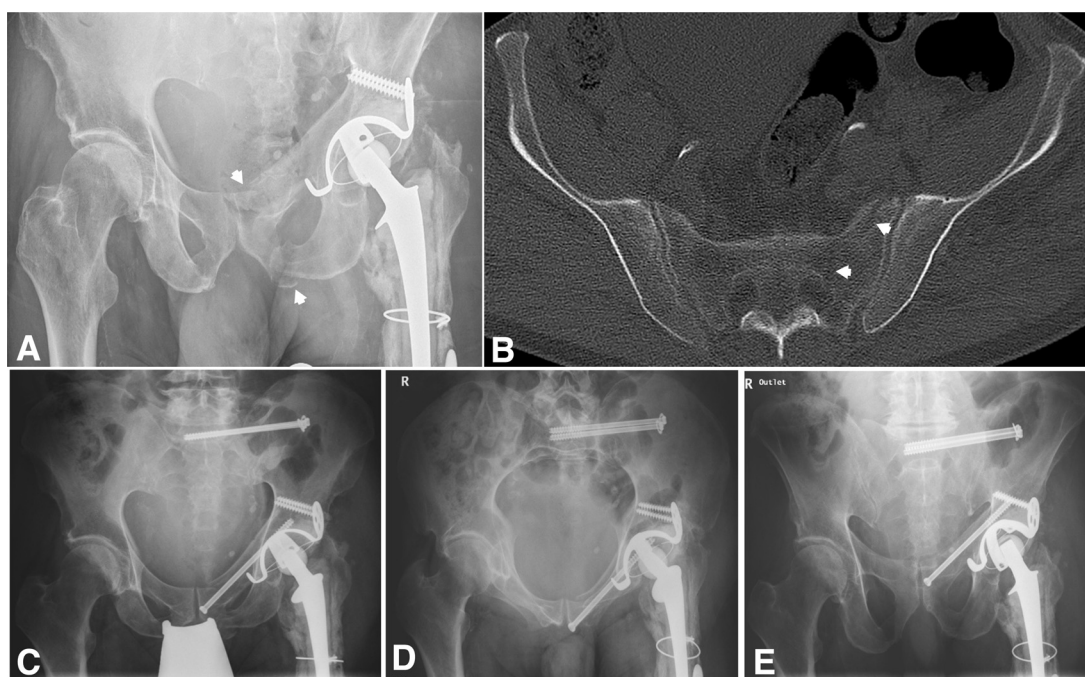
FFP IIIc fracture in a patient with severe osteoporosis was treated using minimally invasive iliosacral and retrograde transpubic screw osteosynthesis. Conventional a.p. radiograph showing the disruption of the anterior pelvic ring (A). Additional CT-diagnostic reveals an additional fracture of the sacral ala on the left site (B). (C–D) Postoperative a.p., inlet, and outlet views.
